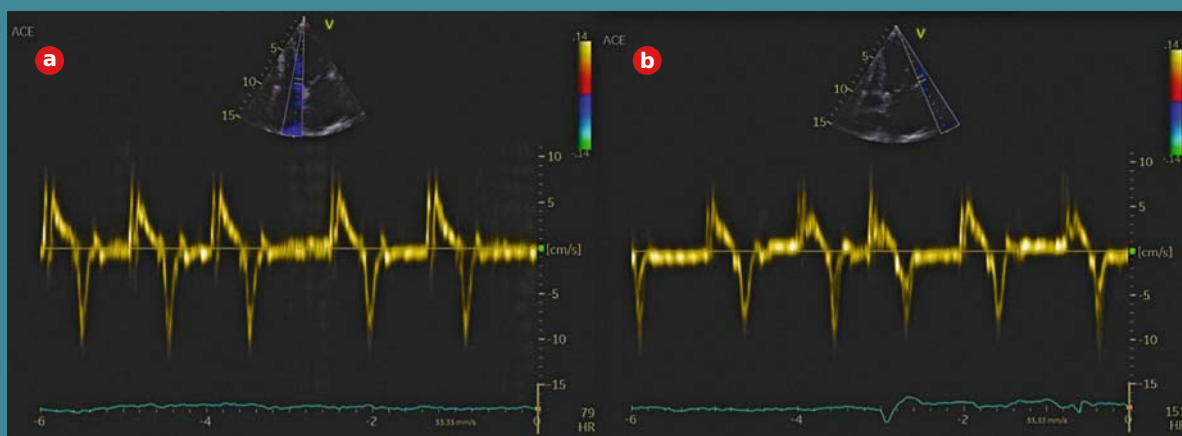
Transthoracic Echocardiography. (A) Septal e' and (B) Lateral e' measured through Tissue Doppler Imaging from an apical four chamber view.
